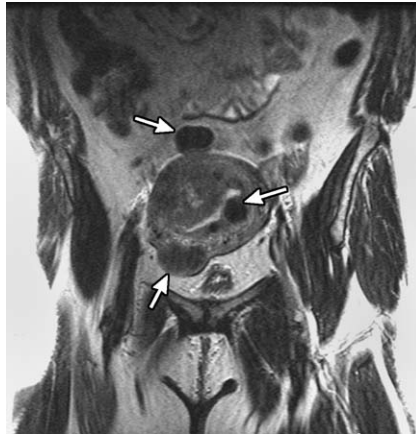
Coronal T2-weighted scan shows three myomas: one submucosal and two subserosal (*arrows*). Heterogeneity in the posterior wall is adenomyosis.
